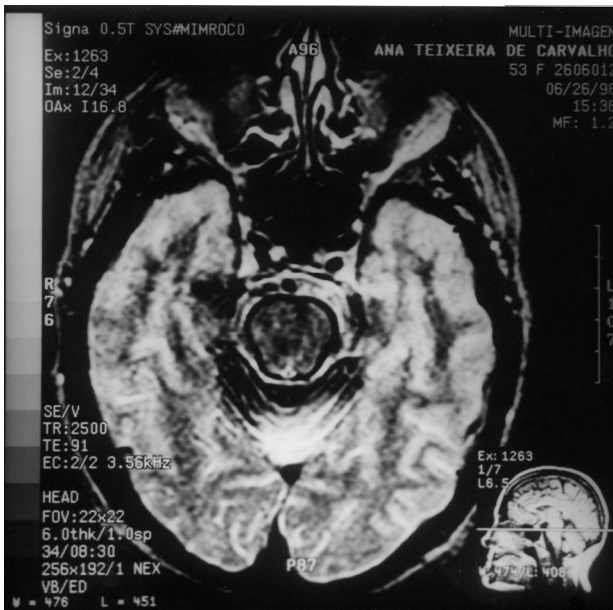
MRI axial section in T2 weighted shows low signal intensity, consistent with haemosiderin deposition, around the mid-brain and cerebellum.
